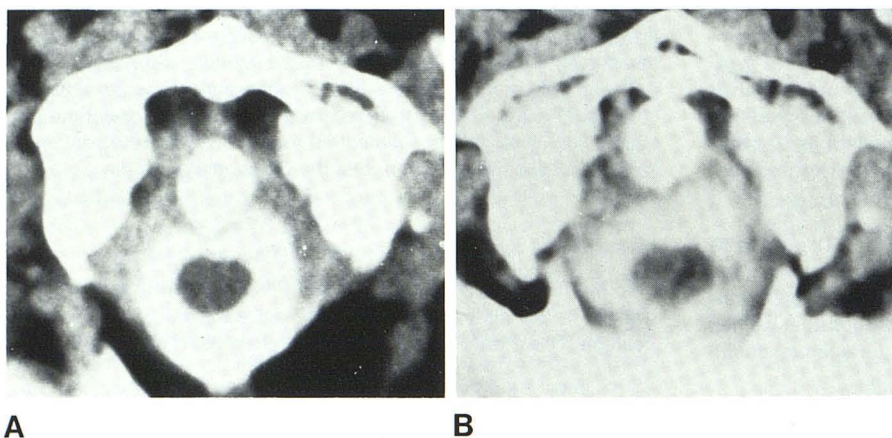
Flexion (A) and extension (B) metrizamide-enhanced CT examinations of craniocervical junction in 54-year-old rheumatoid arthritic patient presenting with myelopathy. Striking displacement of dens on flexion, correction in extension, and change in position of cord in dural sac.
